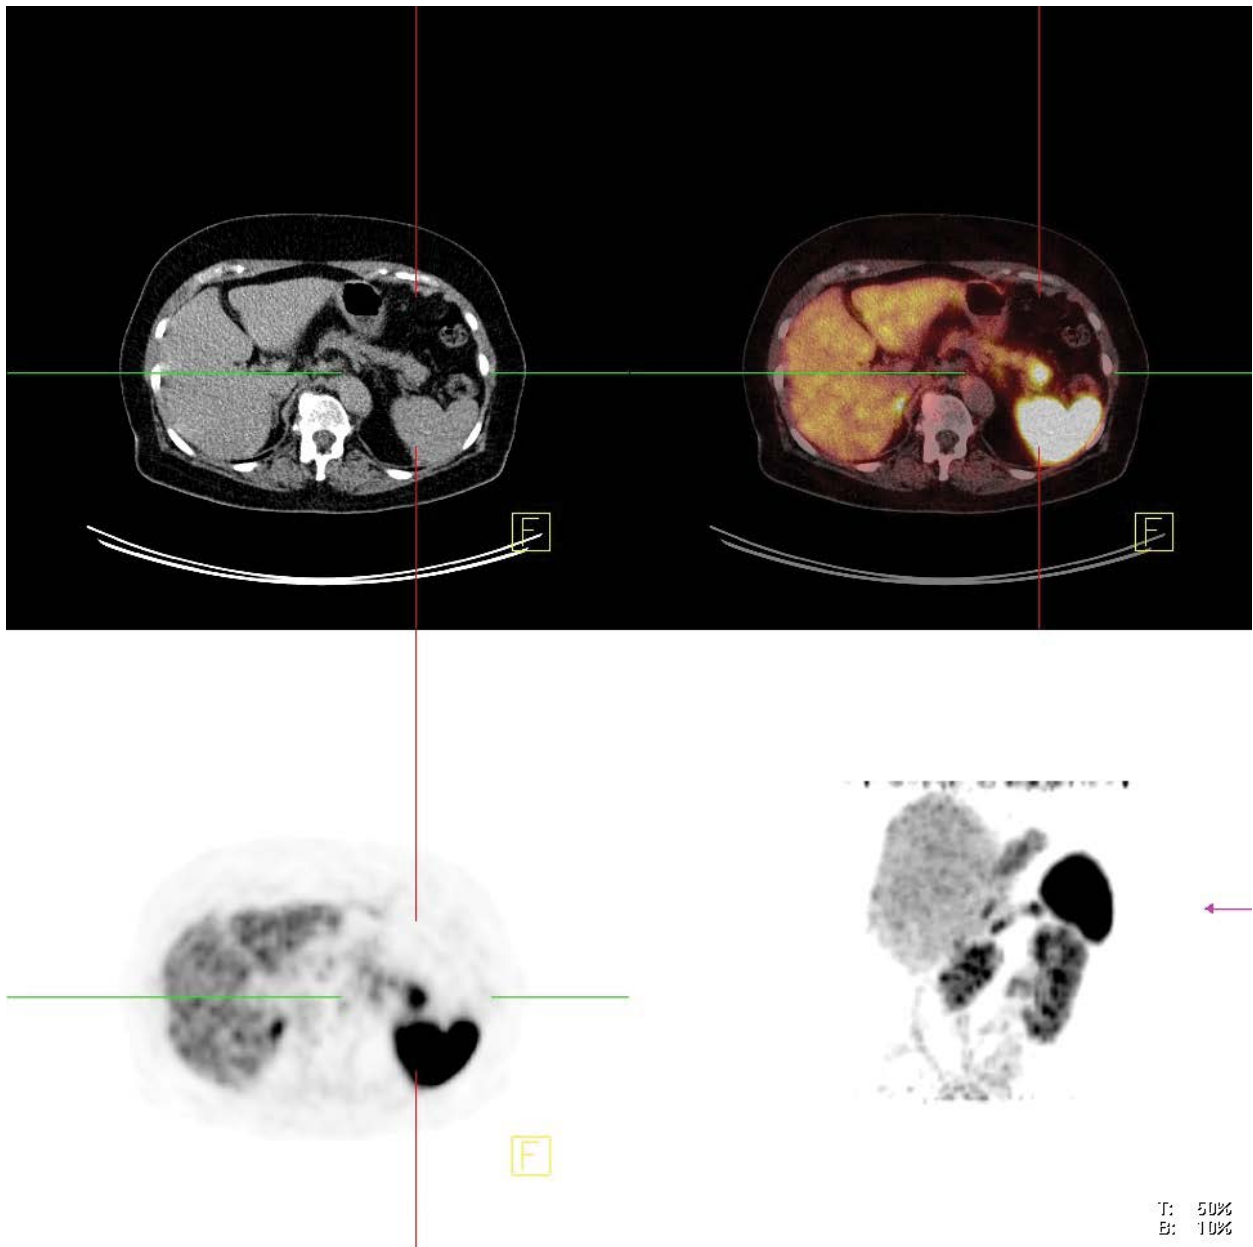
Ga-68-DOTATOC-PET/CT shows an 18x20mm contrast-enhancing lesion in the pancreatic tail. Next to physiologic uptake of Ga-68-DOTATOC-PET/CT in spleen, adrenals, kidneys and urine bladder there was a focal uptake, seen in the suspicious part of the pancreatic tail as seen in the CT scan (arrows).
